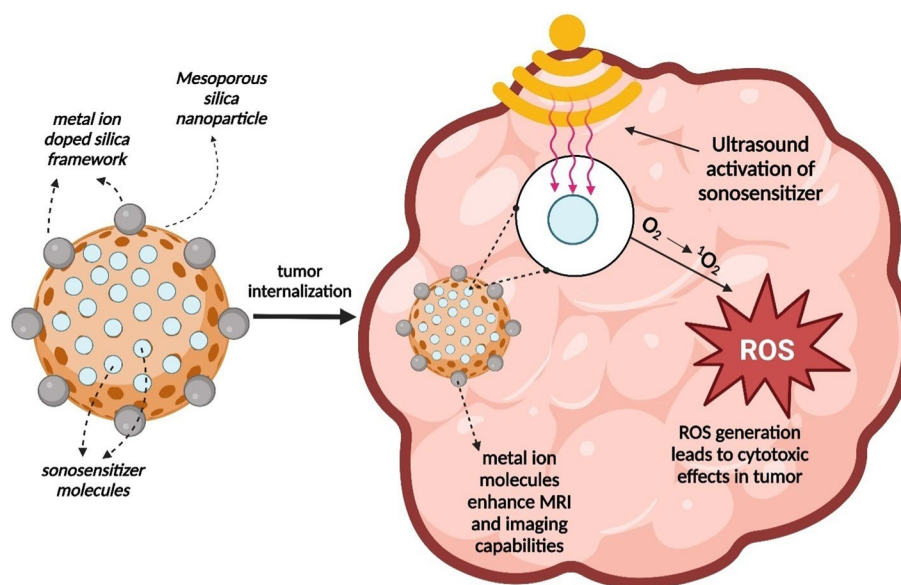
Graphical representation of sonosensitizer-incorporated theranostic MSN platform based on ultrasound as a trigger for cancer therapy
